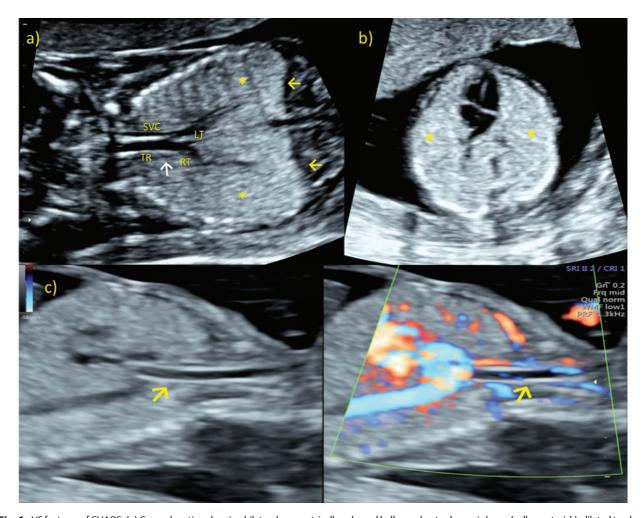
US features of CHAOS. (a) Coronal section showing bilateral symmetrically enlarged ballooned out echogenic lungs (yellow asterisk), dilated tracheabronchial tree (white arrow), flattened/everted diaphragm (yellow arrow). (b) Axial section showing bilateral symmetrically enlarged ballooned out echogenic lungs (yellow asterisk) with mesocardia. (c) Sagittal section—grayscale and color Doppler showing dilated trachea-bronchial tree (yellow arrow). CHAOS, congenital high airway obstruction syndrome; SVC, superior vena cava; TR, trachea; US, ultrasound.
